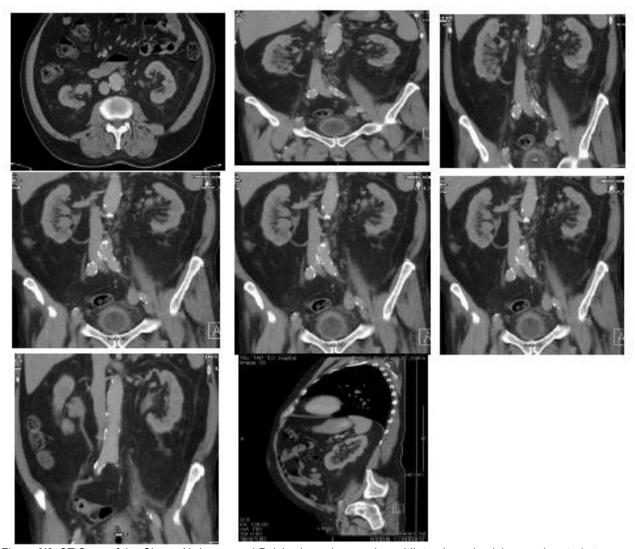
CT Scan of the Chest, Abdomen and Pelvis shows large volume bilateral renal pelvises and ureteric tumours
